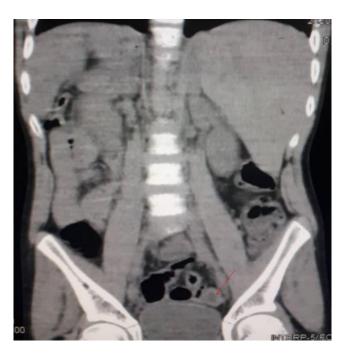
Coronal CT scan of the abdomen showed transposition of the abdominal organs and inflamed appendix (red arrow).
